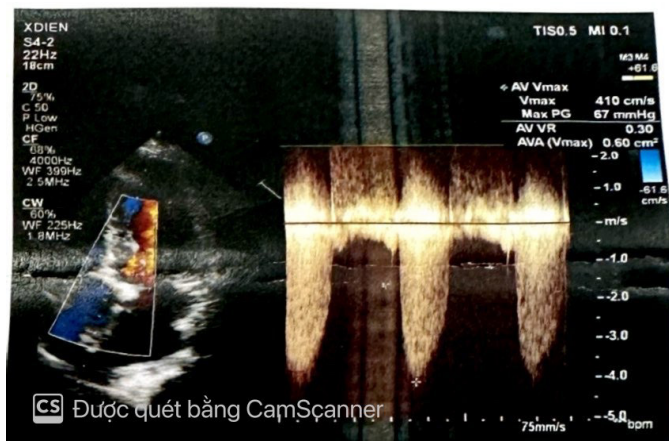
Continuous wave Doppler Echography revealed Vmax 4.10 m/s, maximum pressure gradient 67 mmHg, AVA 0.6 cm².
